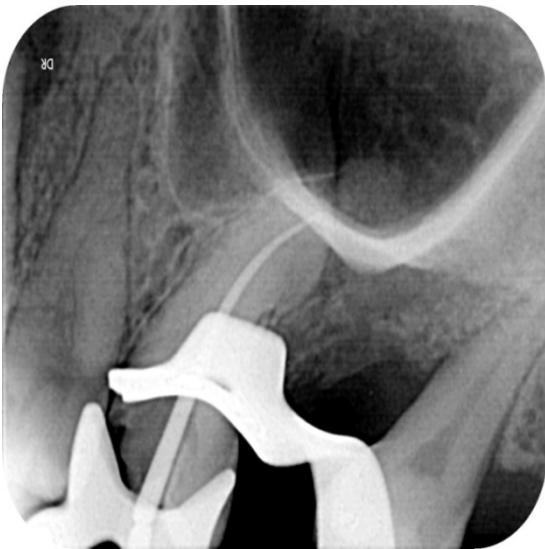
Master cone IOPA radiograph of tooth #26
